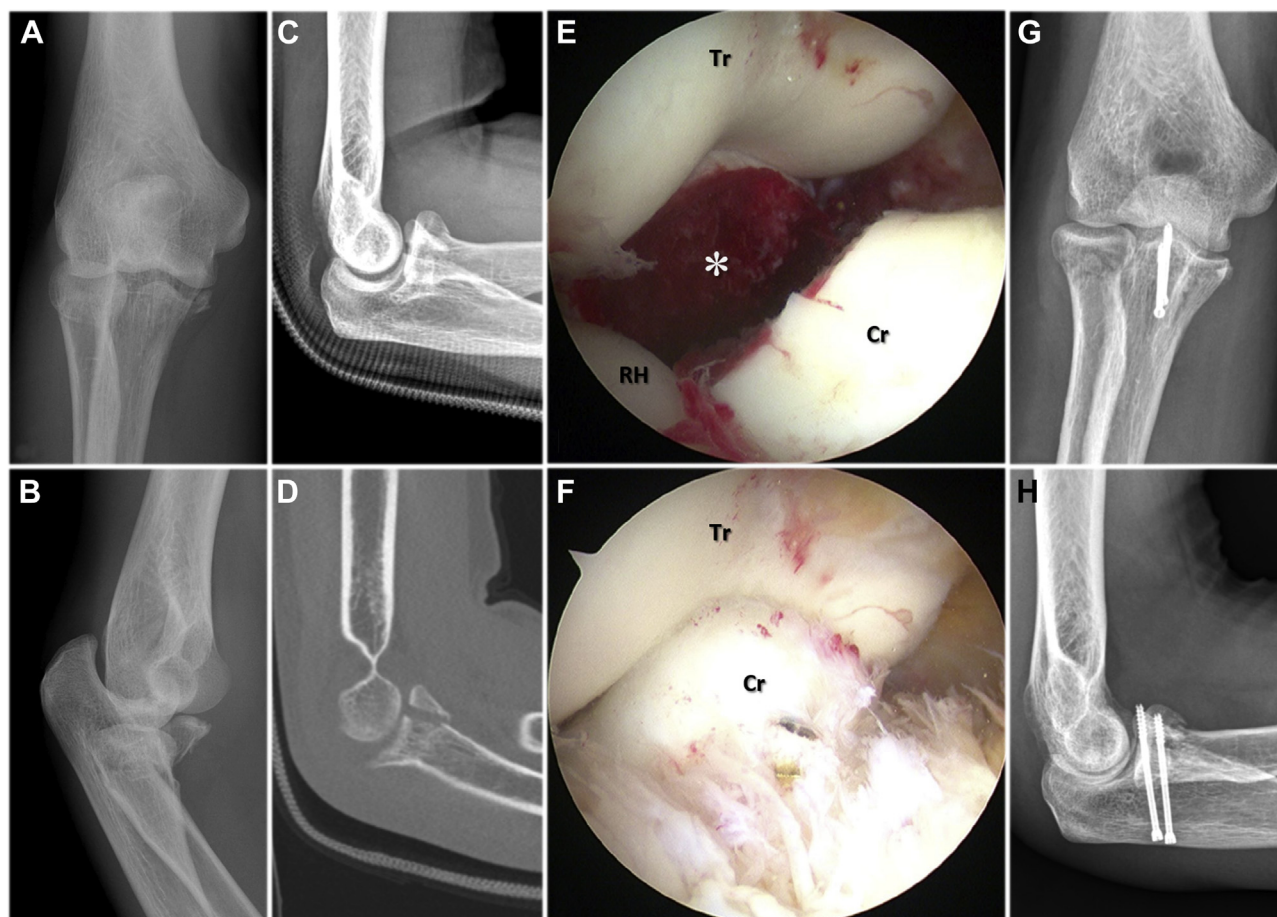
Arthroscopy-assisted reduction and fixation for coronoid fracture in a posterolateral rotatory instability (PLRI) patient. (A, B) Anteroposterior and lateral views of the preoperative radiographs of a 47-year-old man showing the coronoid and combined radial neck fractures of the right elbow. (C, D) Lateral view of a radiograph and sagittal view of a CT showing less than 50% involvement of the coronoid height. (E, F) Proximal anterolateral viewing portal showing the coronoid fracture (*). Anatomic reduction and fixation was performed. (G, H) Anteroposterior and lateral views of radiographs after conducting the arthroscopy-assisted reduction and fixation for the coronoid fracture, open reduction for the radial neck fracture, and open repair for the lateral ulnar collateral ligament. *Tr*, trochlea; *RH*, radial head; *Cr*, coronoid process.
